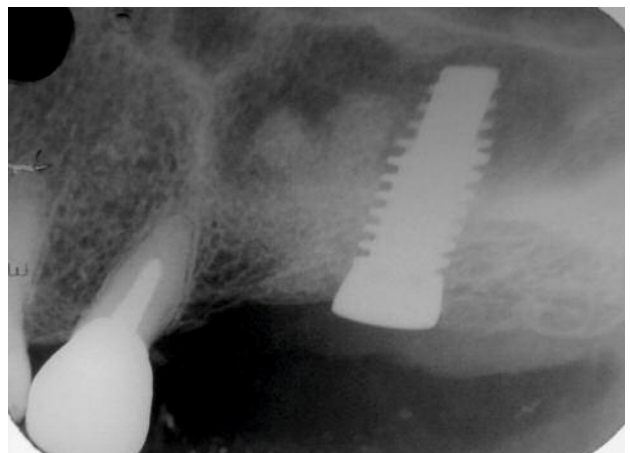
X-ray image showing the placement of the implant.
